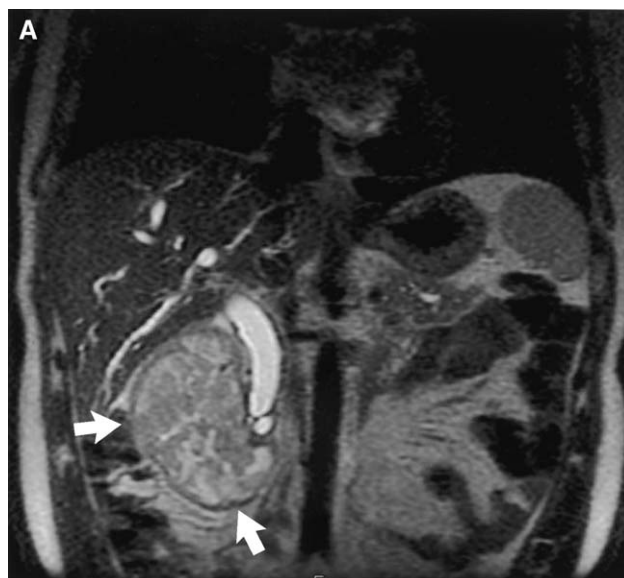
Magnetic resonance imaging coronal section showing a large, bilobed soft tissue mass (*arrows*) involving the ampulla of Vater and compressing both the duodenum and head of the pancreas (A). MRCP study showing the mass (*arrows*) causing obstruction of both the bile and pancreatic ducts (B).
